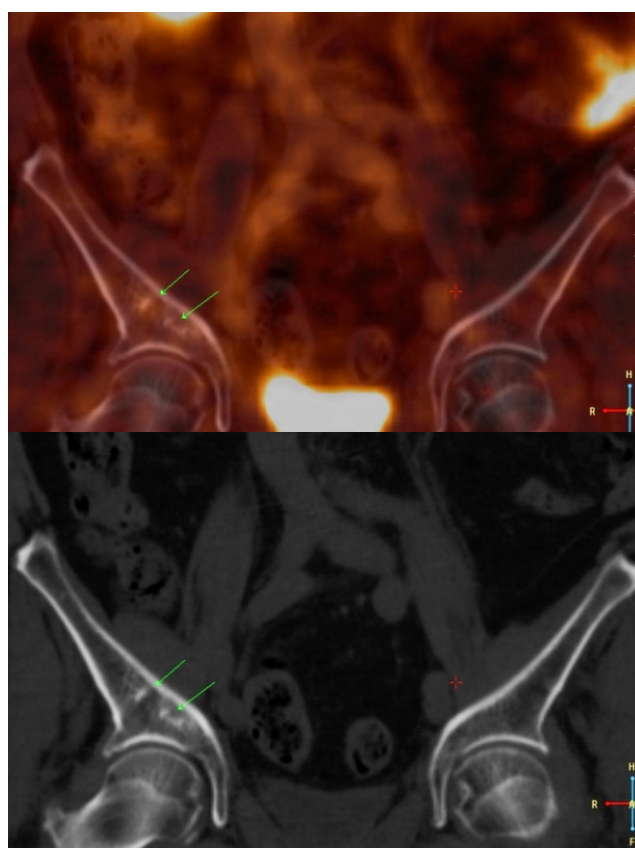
Gallium-68-PSMA-11 PET/CT transverse fused images and a CT images of the same patient 43 months later with same lesions- a PSMA positive discrete osteosclerotic lesion in the left iliac bone and 7<sup>th</sup> rib on the right.
